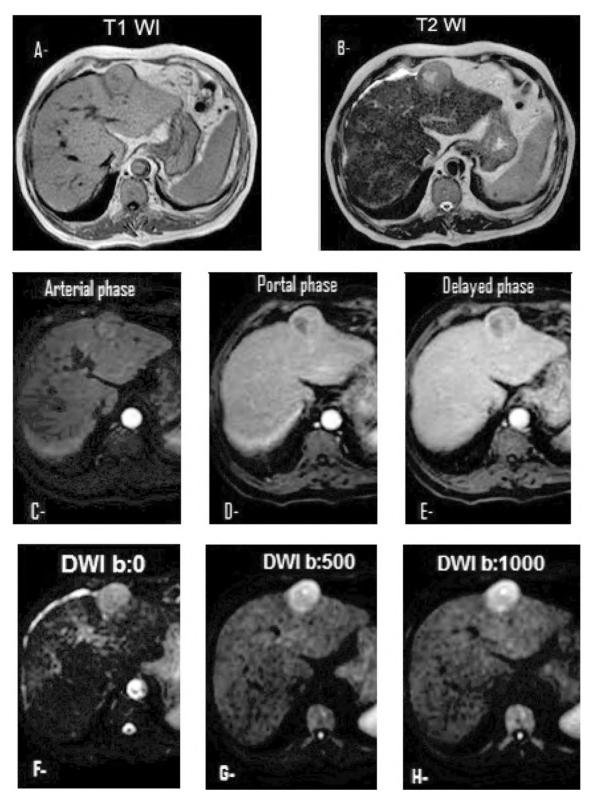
(A-H): 65 year old male patient presented with abdominal pain mainly at the right hypochondrial region. AFP was 625ng/ml. Dynamic MRI study revealed typical hepato-cellular carcinoma. Axial unenhanceded T1W I (A) and T2WI (B) showed a left hepatic lobe mass lesion of mixed iso and low signal intensity on T1 WI and mixed iso and high signal intensity on T2WI image. Axial gadolinium-enhanced arterial-phase image (C), portal phase (D) and delayed venous phase (E), showed early enhancement of the lesion in the arterial phase and rapid washout in the portal and delayed phases with persistent capsular enhancement in the delayed venous phase. On DWI (b: 0,500, 1000) (F, G and H) respectively; showed increase in the signal intensity (diffusion restriction) by increasing the b value. Axial ADC map (not shown) showed the lesion to be of decreased signal intensity, with ADC value was $1.06x10^{-3}$ mm²/sec. proving that the high signal intensity on DWI was not T2 shine-through effect, but a truly restricted diffusion.
